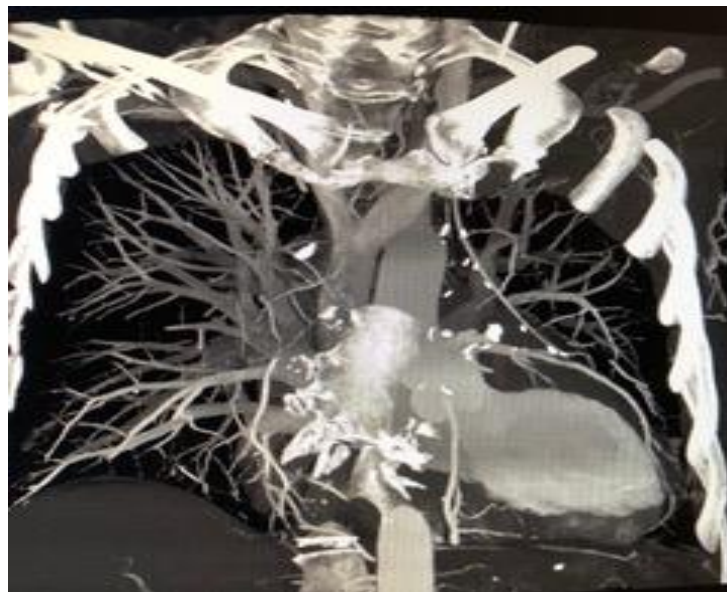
Post operative coronary CTA demonstrates patency of the LIMA to LAD anastomosis.
